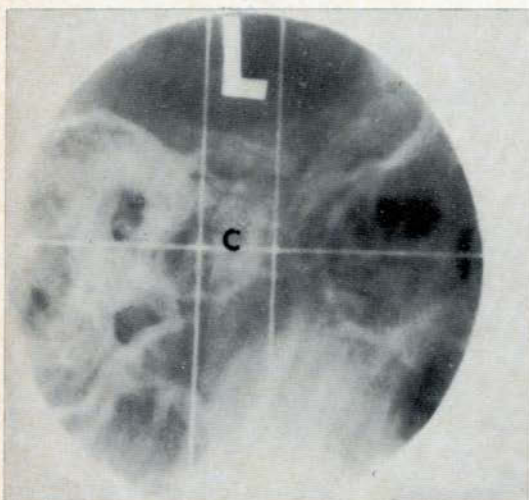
A standard temporomandibular joint radiograph at approximately the same magnification, shows much less detail.
